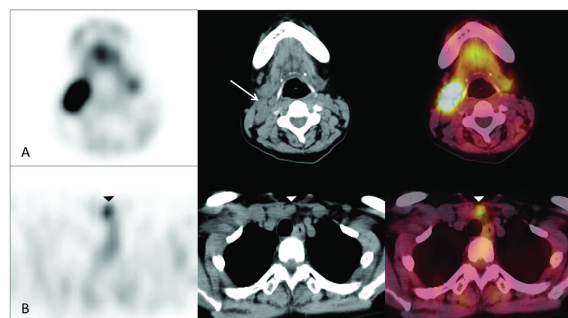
Example of positive MIBI SPECT/CT scan. Transaxial MIBI images (left), CT images (middle) and fused images (right) in a patient with pathological proven right level II (A) and level VI (B) cervical nodal metastases. Note that CT adds value in identifying right level II lymph node (arrow) adjacent to right submandibular gland which shows inseparable MIBI activity from physiologic submandibular activity. This case also demonstrates that MIBI can be taken up even in subcentimeter node (B, arrow head) which is below CT size criteria for positive cervical nodal metastasis.
